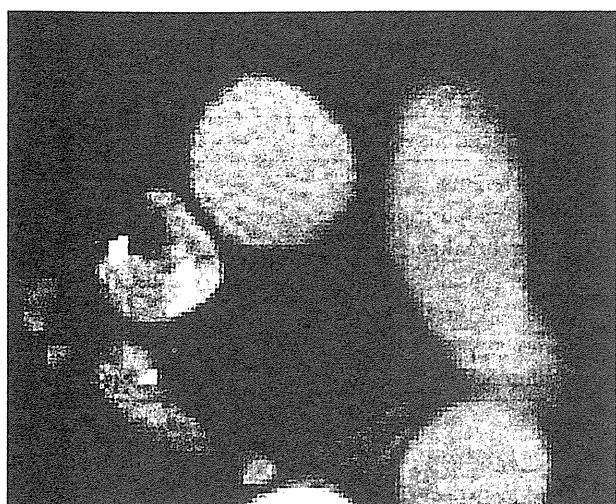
Enhanced CT showed the catheter tip thrombus.
